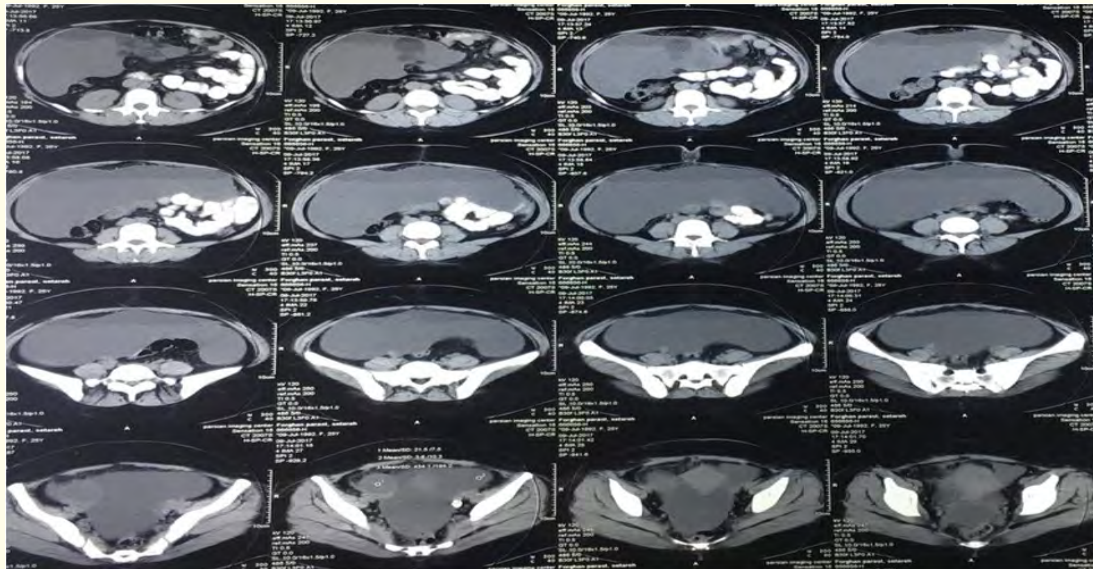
Computed tomography scan reveals A huge multilocular fluid-filled cyst from upper abdominal region downward to the pelvis.
